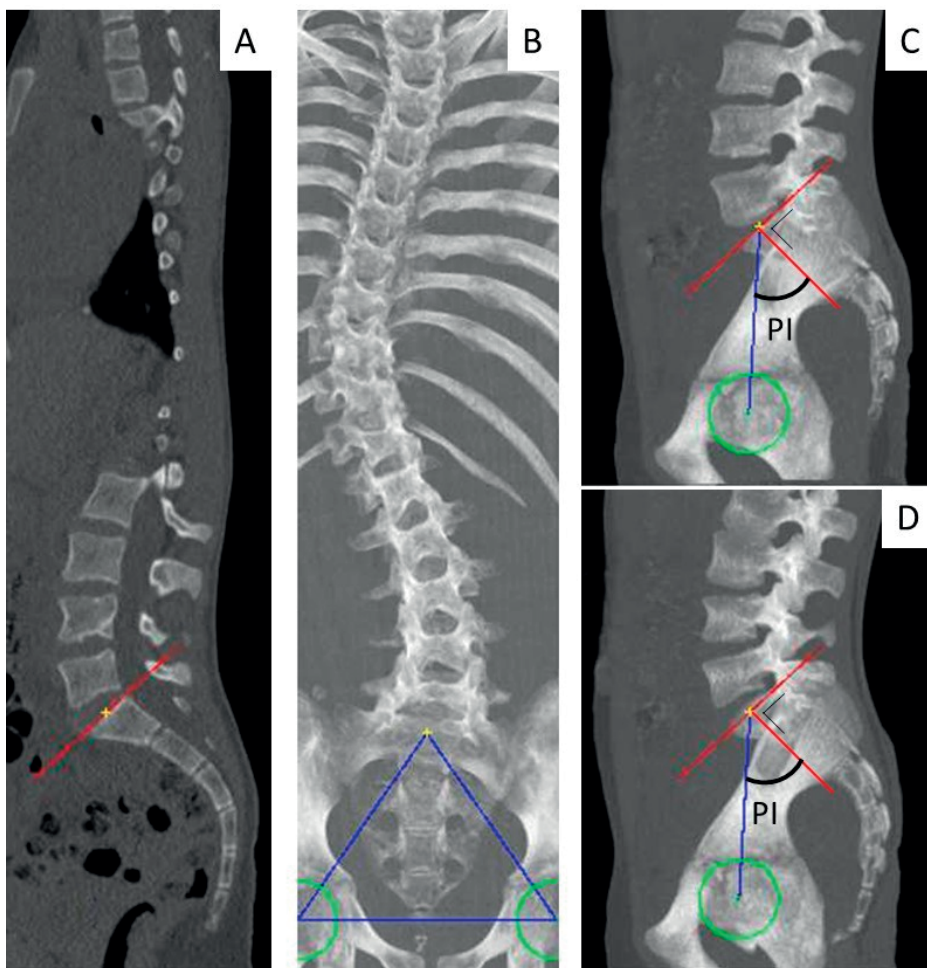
Computerized measurement of the pelvic incidence (PI) on a computed tomography scan. The center and inclination of the sacral endplate (A and B) and the centers of the left and right femoral heads (C and D) were used to calculate the PI. The computerized method automatically determined the exact centers of the femoral heads in three dimensions (3D) from the spheres that best fit to the 3D edges of the femoral heads. The exact center of the sacral endplate in 3D was automatically determined by locating the sacral endplate and finding the midpoint of the lines between the anterior and posterior edge and between the left and right edge of the endplate. The previously validated computerized method was used to measure the PI in 3D images, based on previously validated image-processing techniques, as the angle between the line orthogonal to the inclination of the sacral endplate and the line connecting the center of the sacral endplate with the hip axis⁸⁷.
